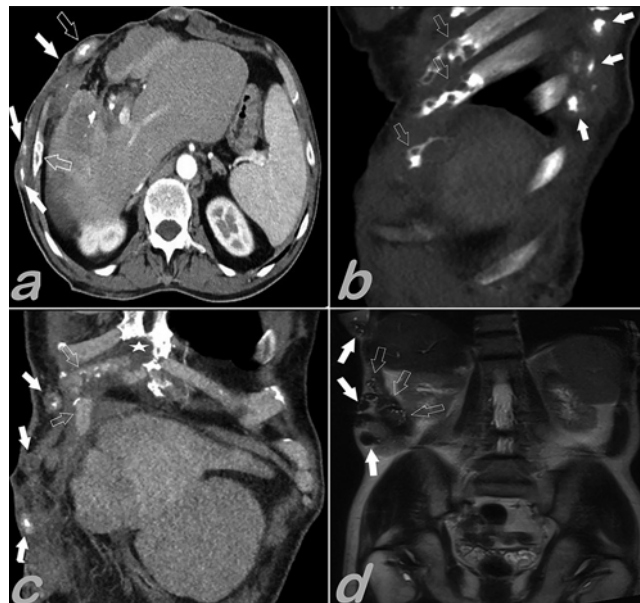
(a–d) Abdominal CT scan, axial slice (a), sagittal (b), coronal (c), and coronal T2-weighted magnetic resonance imaging (d) show local metastasis to the skin, subcutaneous tissue (solid arrows), pleura, ribs (empty arrows) and sternum xiphoid process (white star).
